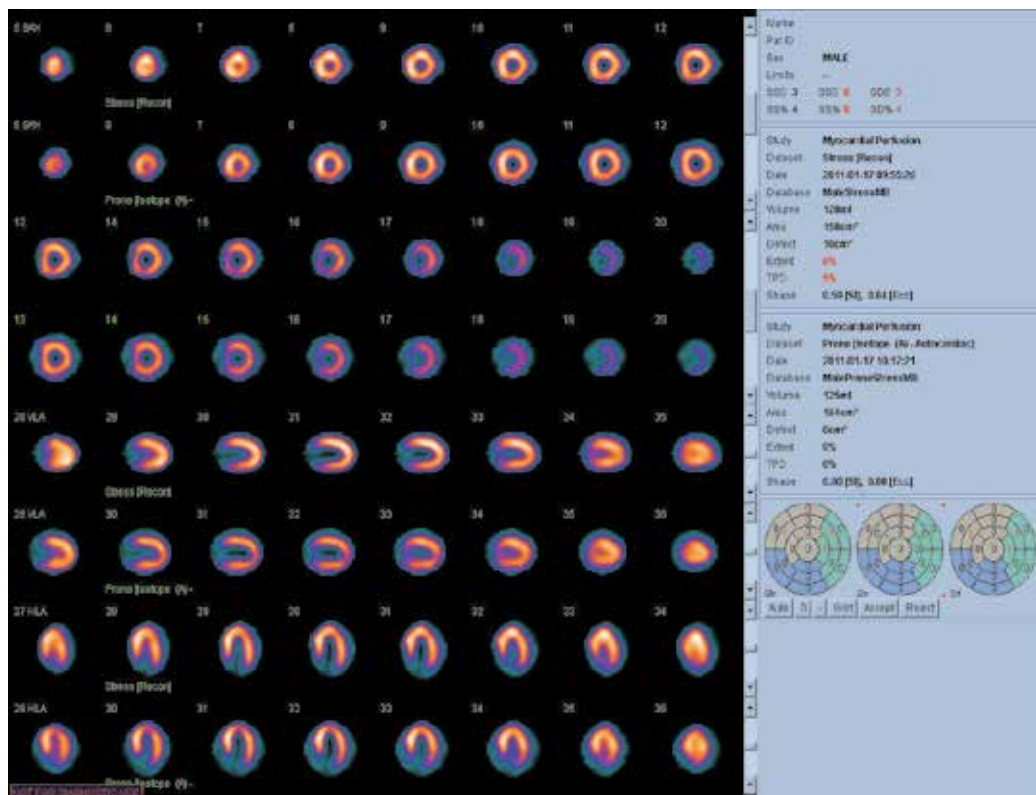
Myocardial scintigraphy - dilative cardiomyopathy with no ischemic area.
